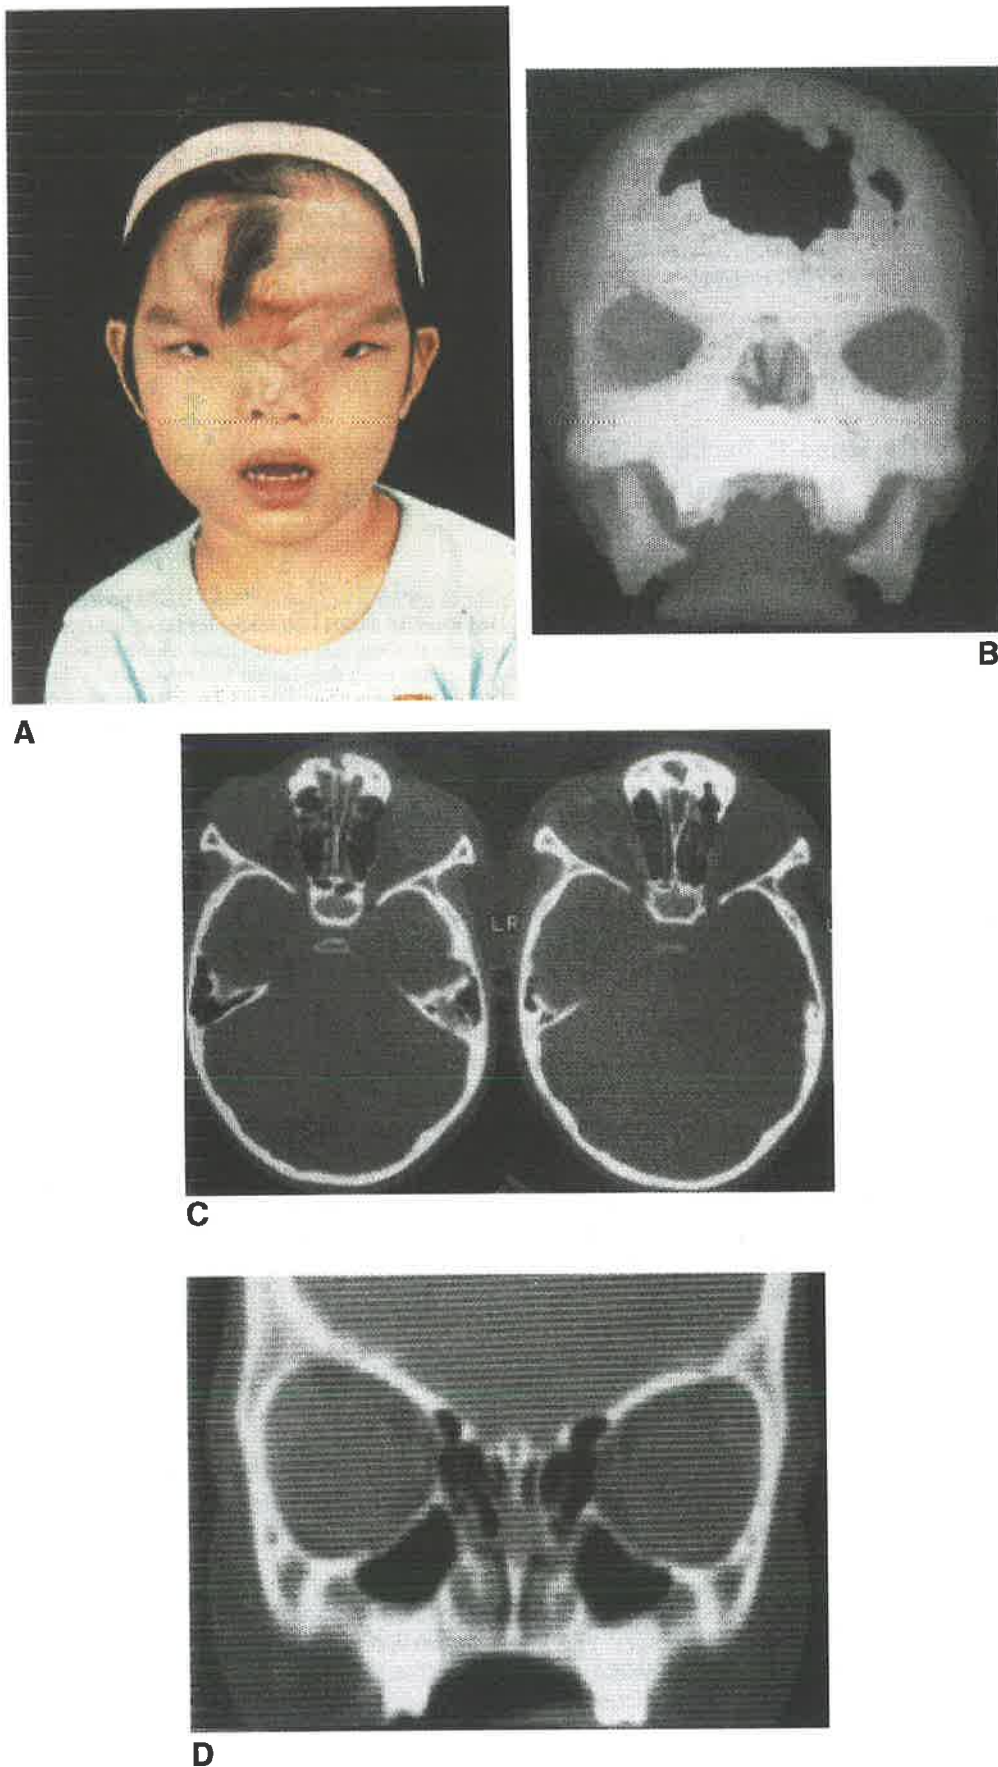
A. Four-year-old Malaysian girl with previously operated midline craniofacial clefts of the Tessier Number 0–14 type. B. Three-dimensional CT reconstruction reveals the orbital hypertelorism below and extensive median frontal defect above. C. Marked widening and extensive pneumatization of the ethmoid sinuses, with associated bifid perpendicular plate. D. Coronal two-dimensional CT reformat exposes the inferior prolapse of the widened ethmoid sinus with a characteristic harlequin appearance.*
